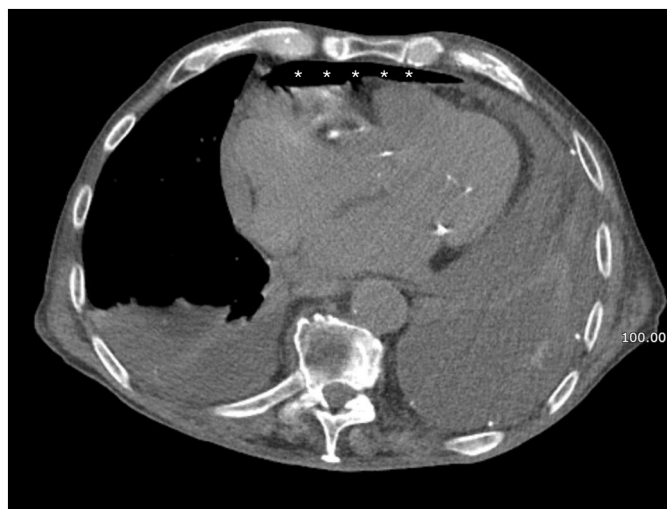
Computed tomography of the chest revealing a small layer of air (asterisks) inside the pericardial space, located in the retrosternal area.
